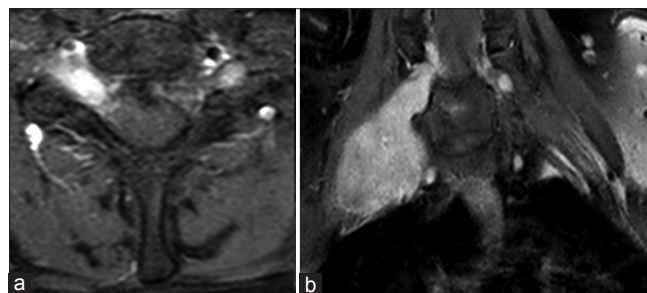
Preoperative axial (a) and coronal (b) MRI with contrast showing a predominantly extradural tumor component (patient 3)
